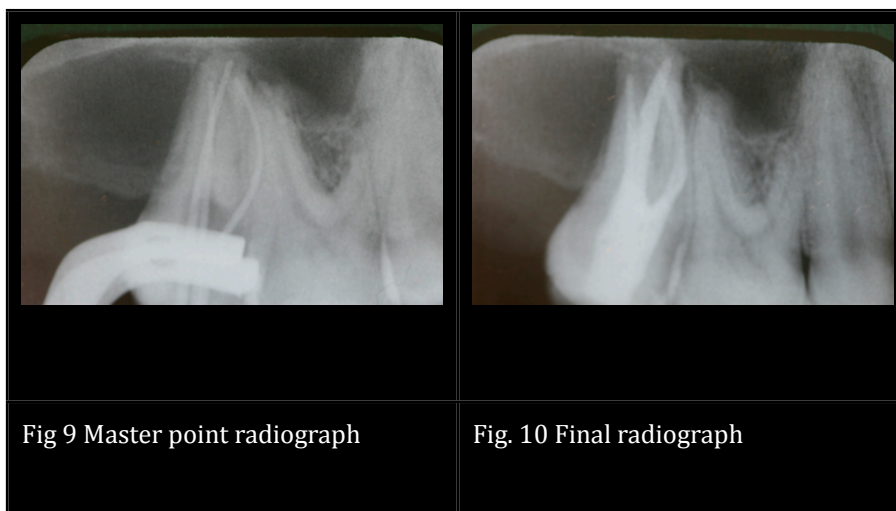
Master point radiograph
